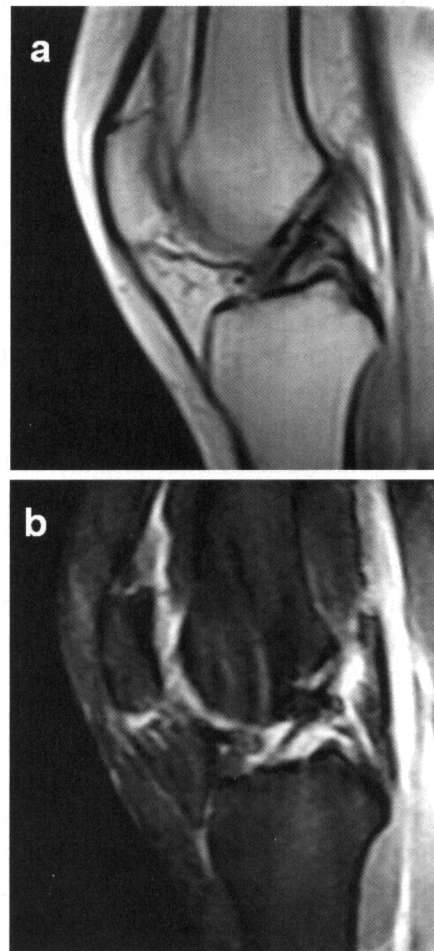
a)* T1- and T2-weighted sagittal MRI *(b)* showing the complete excision of the lesion with no signs of recurrence at 5-month follow-up.
